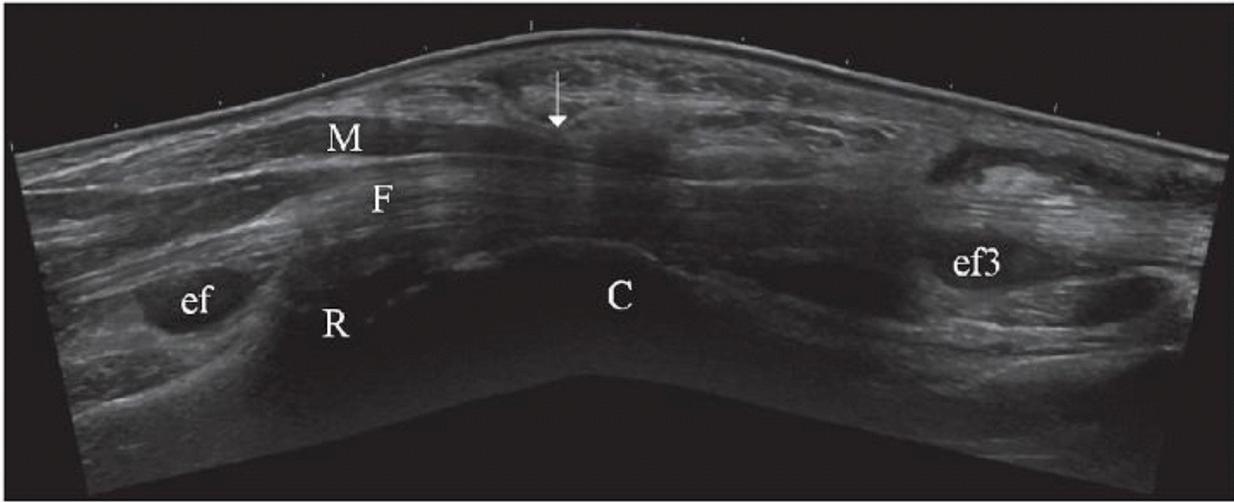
Tenosynovitis of the flexor digitorum tendons of the long finger (F). Longitudinal ultrasound scan shows effusion in the flexor tendon sheath proximal (ef) and distal (ef3) to the carpal tunnel. Median nerve is enlarged proximal to the carpal tunnel (M) and compressed under the flexor retinaculum (arrow). R, radius; C, carpus.
